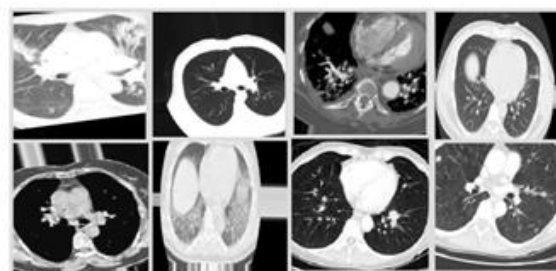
CT scan of two lungs infected with COVID-19 from the dataset
